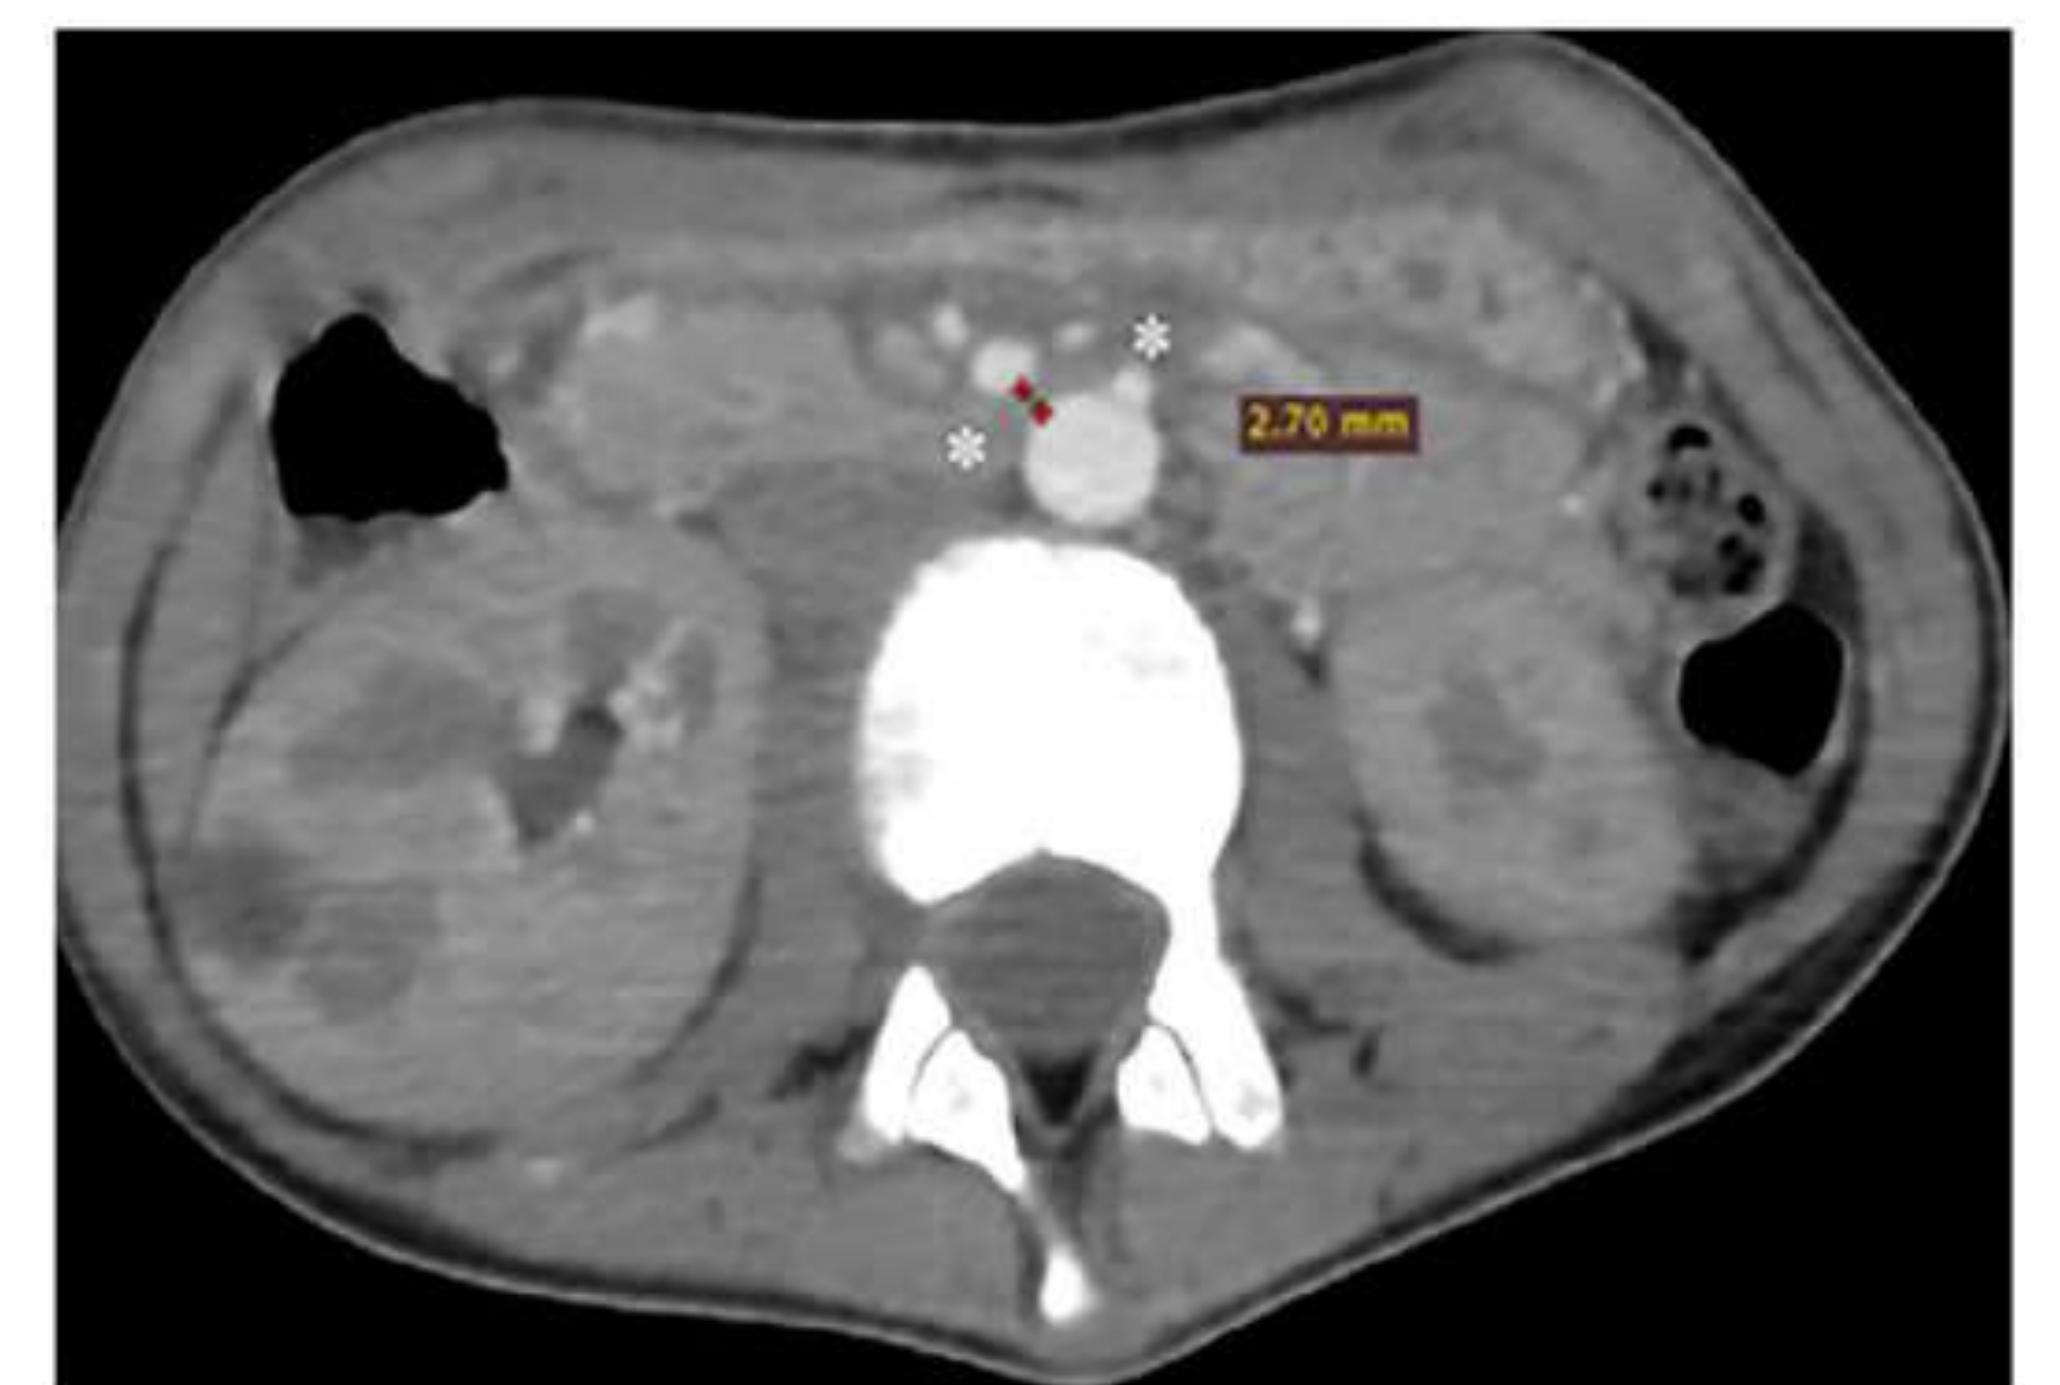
Axial contrast CT scan shows short aorta-SMA distance (2.7 mm) at level of duodenum (asterisk) after inserting a nasogastric tube. (ref 2)
